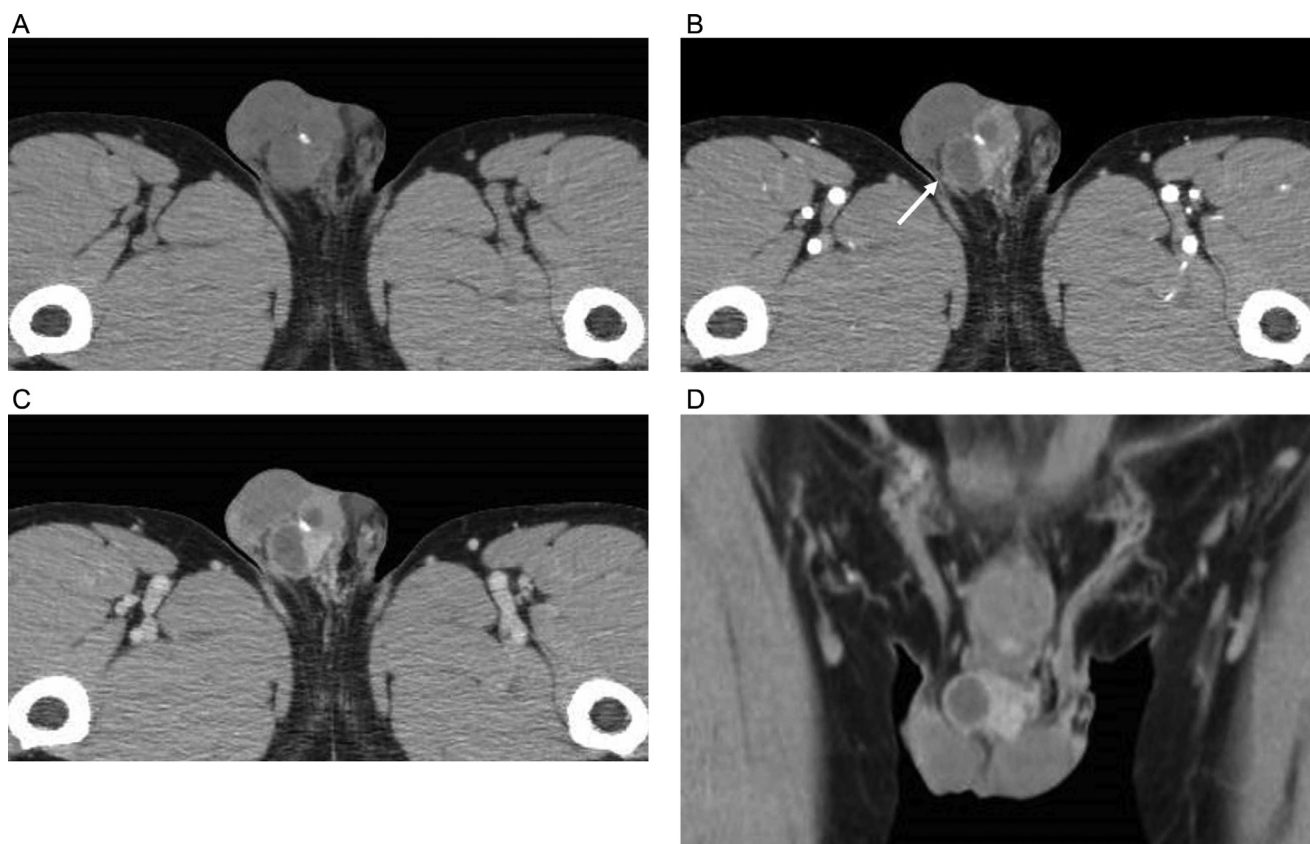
Computed tomography (CT) scans (soft tissue window).
